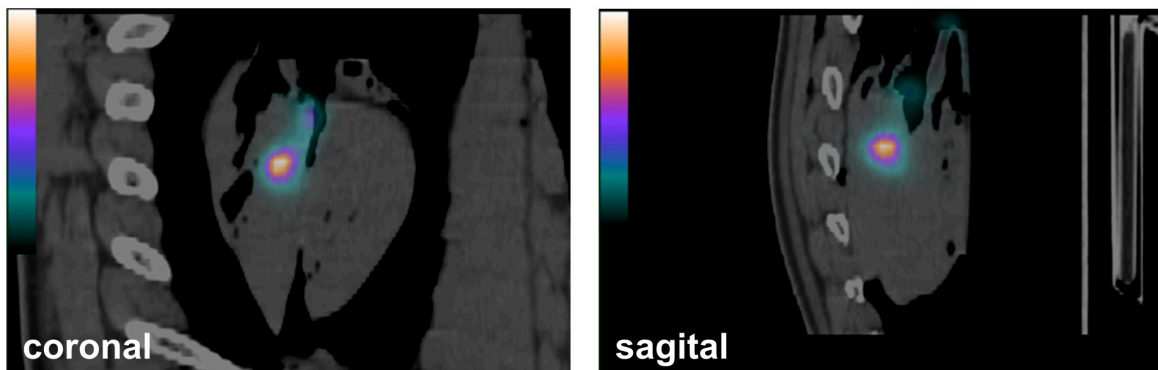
Ex vivo SPECT-CT Imaging ^{123}I markierter NIS^+ -hiPSCs
